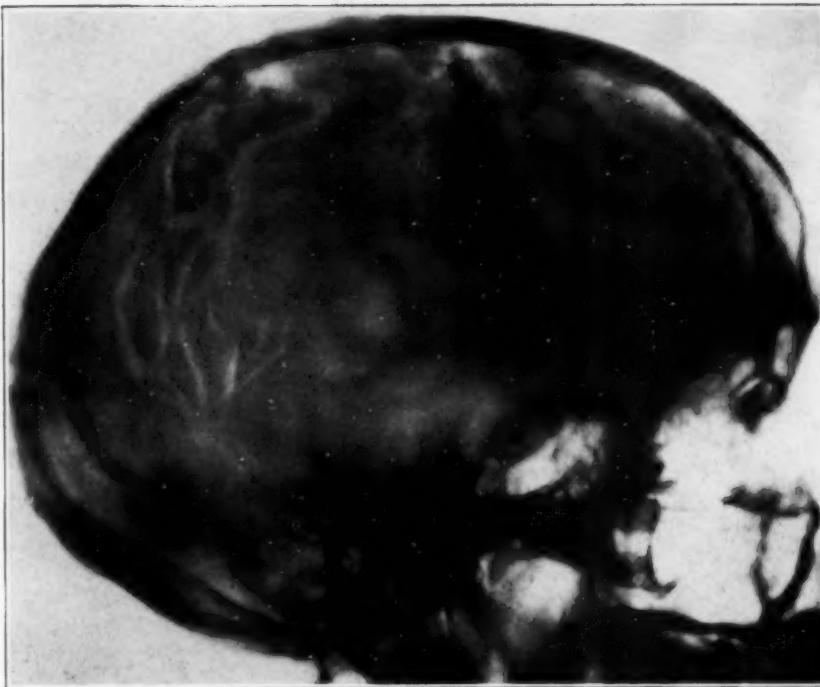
Roentgenogram showing marked increase in size and number of posterior temporal veins on the left. (Plate slightly retouched.) Marked pyramidal tract signs on right side of body, with choked disks.
